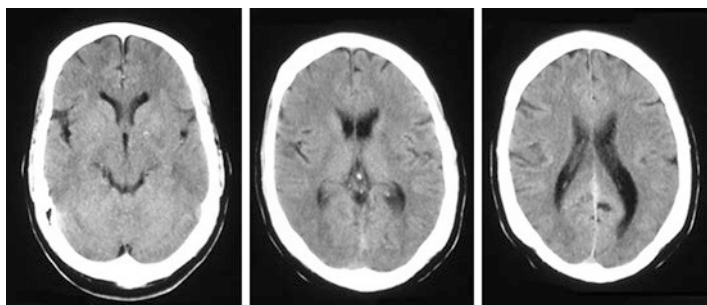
Non-contrast CT scan of a 61-year-old male with sudden onset right hemiplegia two and a half hours prior to the CT scan. He is diabetic and hypertensive. *Given the history most experienced radiologists will identify the subtle differences but it may seem completely normal to a beginner. The CT findings are often only as important as the question it was intended to answer! What was/were the clinical question(s) in requesting a CT scan here? Answer: 1. To see if there was hemorrhage. 2. To see if there is a low-density signifying infarct. 3. Look for any other cause of hemiplegia, e.g. tumor*
